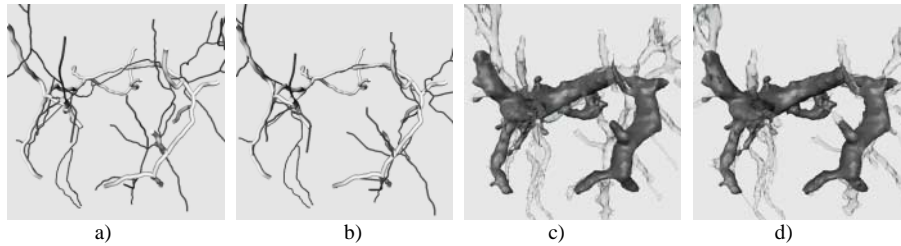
(a) Rigidly and (b) non-rigidly registered portal vein center lines from CT (thin and dark) and 3D US (thick and bright). (c) Rigidly and (d) non-rigidly registered vessel surfaces from CT data (transparent) to 3D US (opaque).
